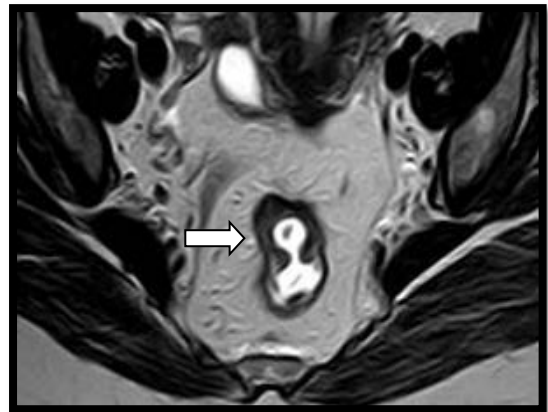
48 years old female with upper rectal cancer. Axial T2-weighted imaging showing uneven circumferential mural thickening, the outermost part of the mass is about 1.5 cm from mesorectal fascia anteriorly.
